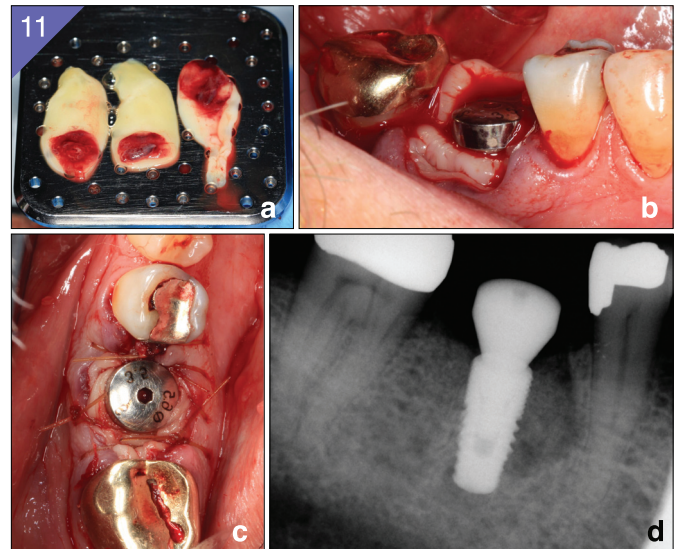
a,b) DENTIS™ S-Clean Implant in place, covered with CGF. c) Chromic gut sutures were used to hold all in place after placing the healing abutment. d) Periapical radiograph of implant position.
